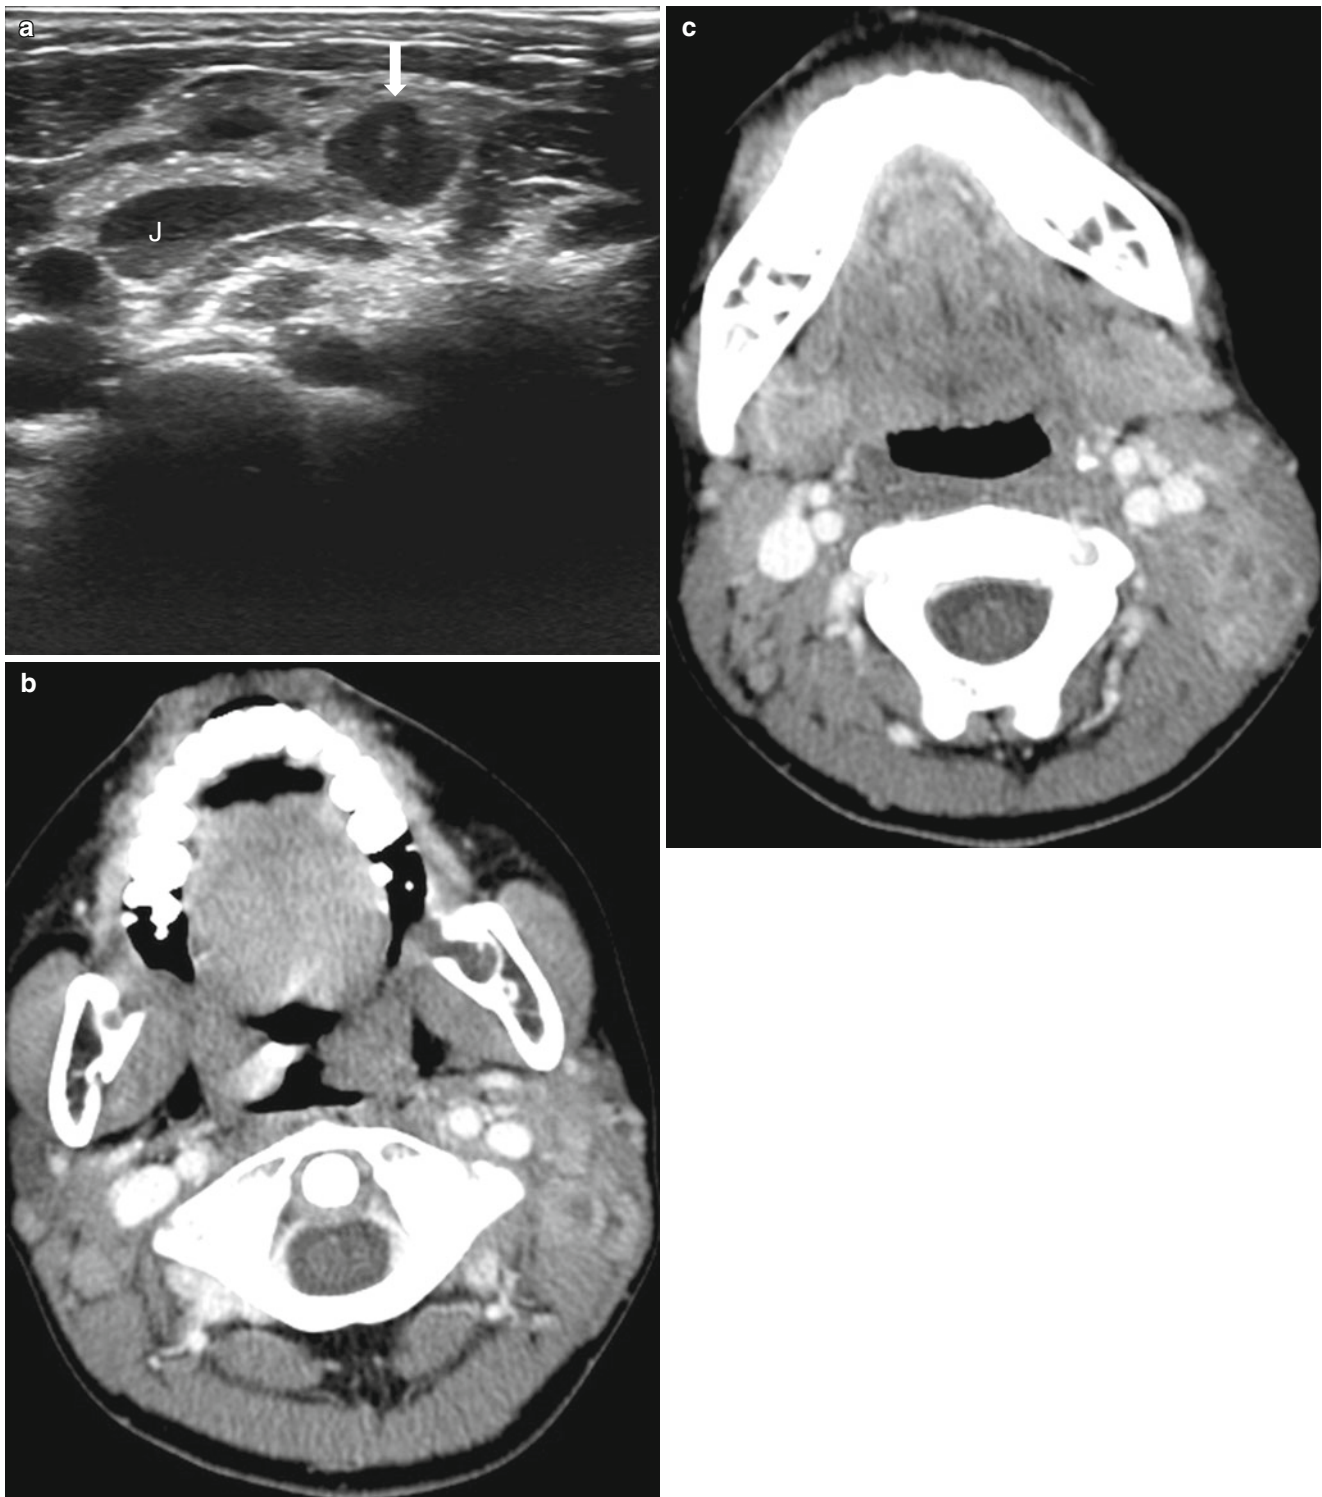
Kikuchi disease in another 13-year-old boy. (a) Ultrasound of the left neck shows a lobulating contoured hypoechoic lesion (*arrow*) representing an enlarged lymph node just lateral to the internal jugular vein (*J*). (b, c) Postcontrast CT of the neck shows conglomerated lymph
